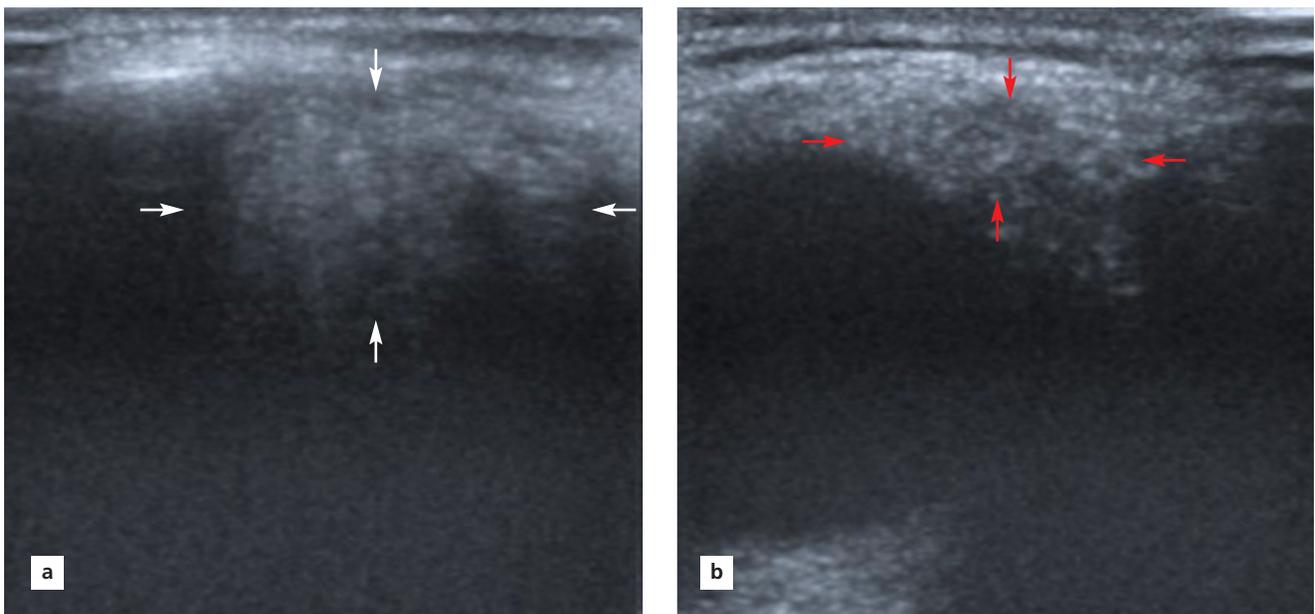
(a) B mode sonography findings of increased echogenicity, inhomogeneity, and enlargement of lacrimal gland (right side) (white arrows), compared to (b) healthy participant (red arrows).
